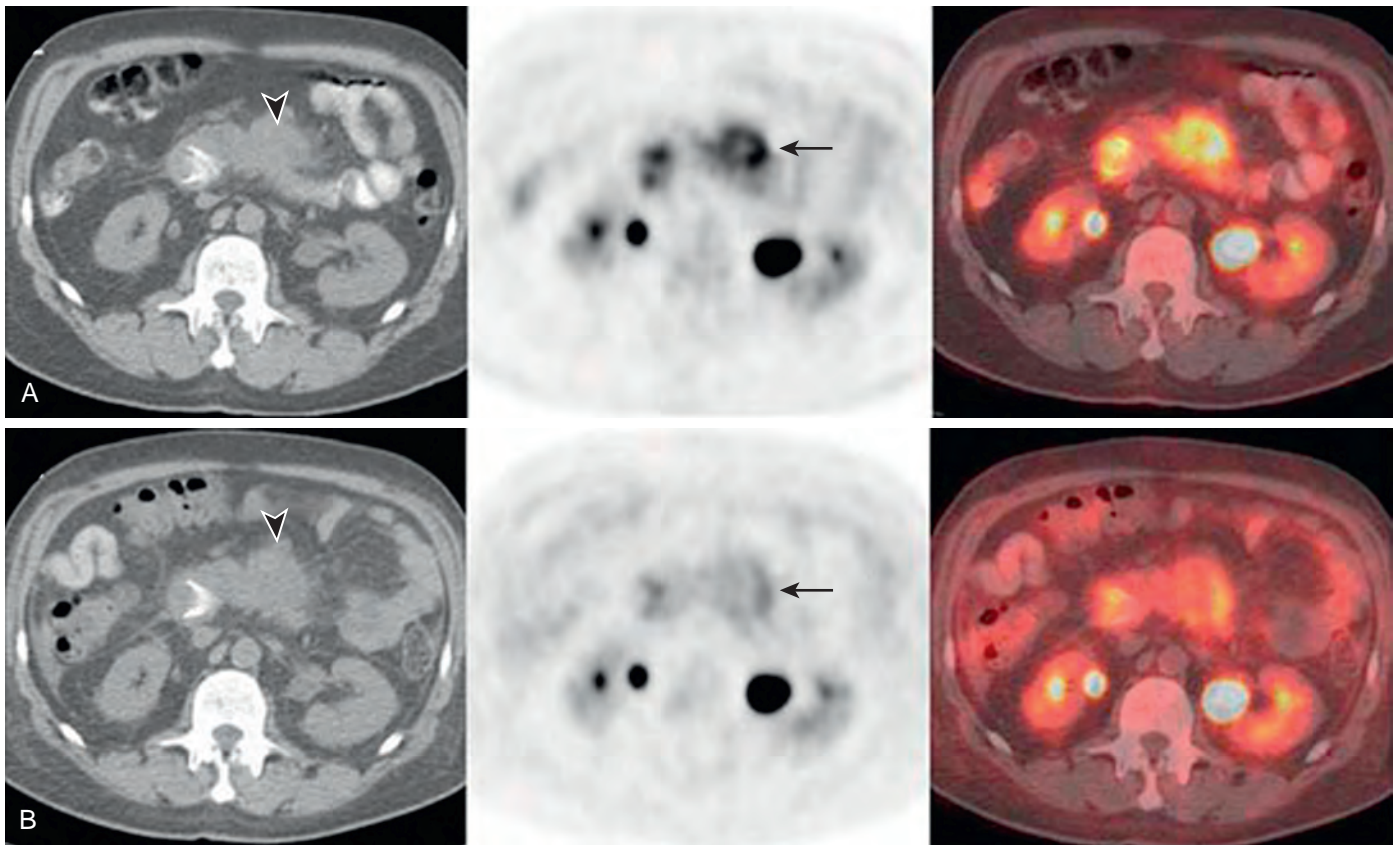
PERCIST criteria. Pretreatment (A) and post-treatment (B) PET/CT image sets in a 59-year-old man with pancreatic cancer demonstrated stable tumor sizes on CT (arrowheads). However, there was 41% decrease in SUL, indicating that tumor (arrows) has responded (partial response). PERCIST compares the metabolically most active lesion as measured with SUL peak.
